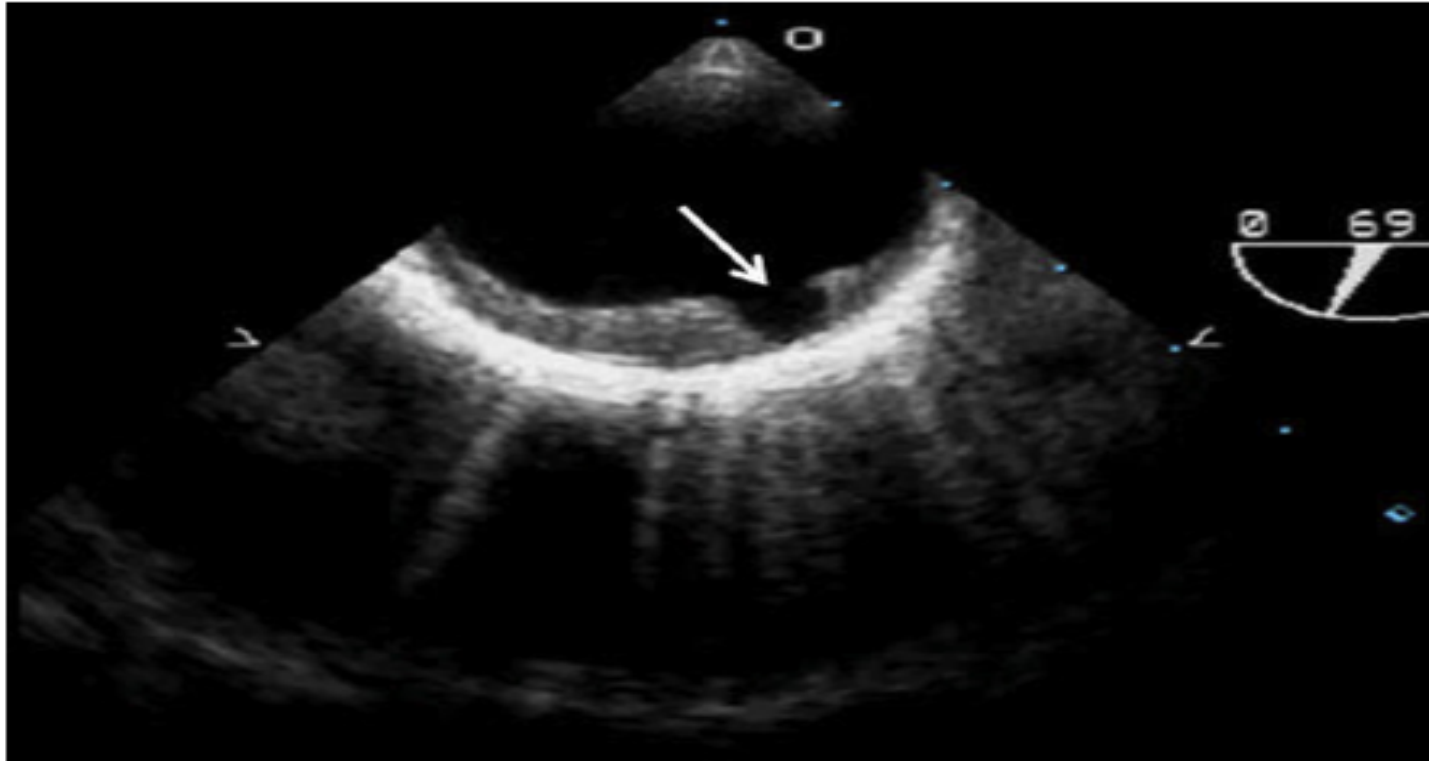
Transesophageal echocardiogram from a patient with a penetrating atherosclerotic ulcer (*arrow*). Note the prominent aortic atheroma (not labeled).
